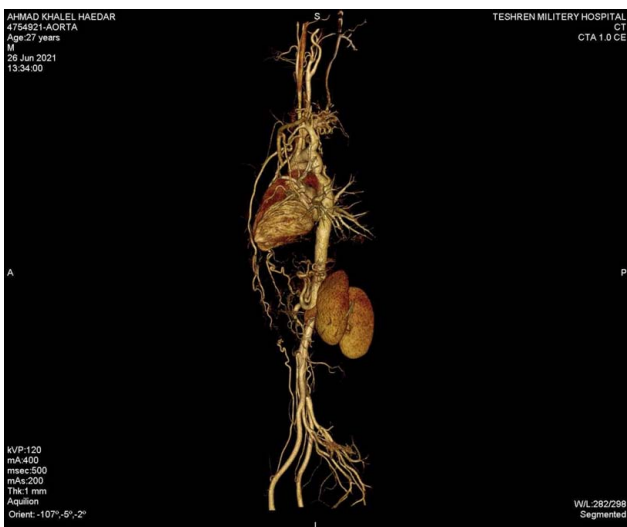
Computed tomography angiography showing the coarctation of aorta.
